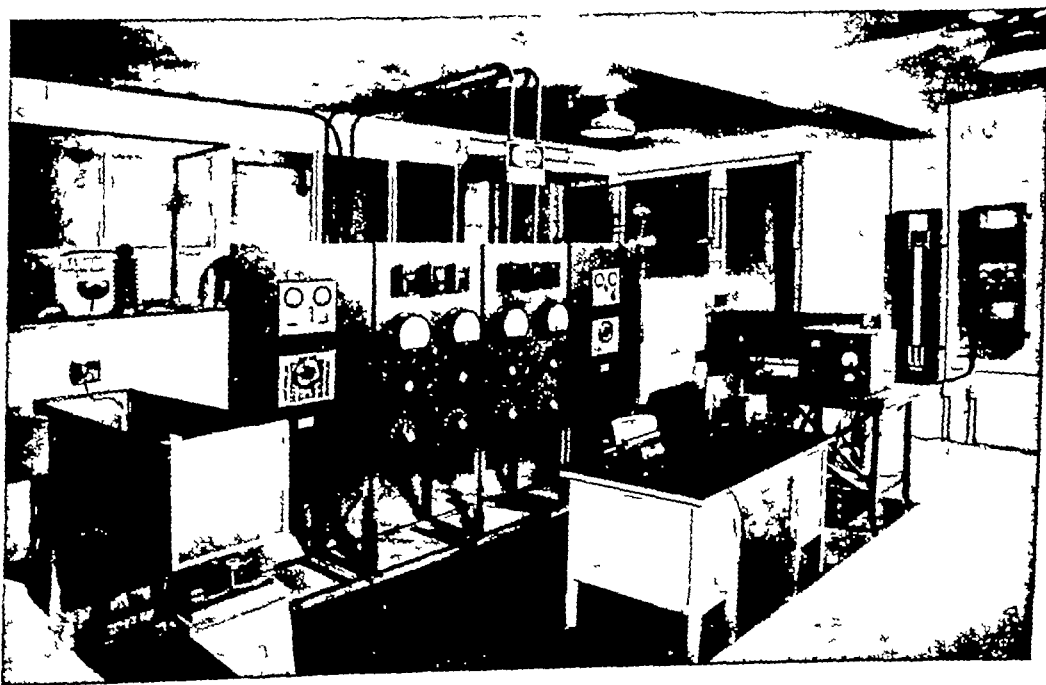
Roentgen ray machines and controls
